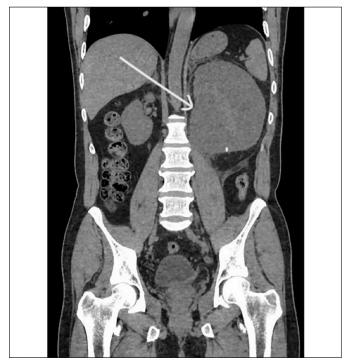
CT KUB showing markedly dilated hydronephrotic left kidney.
